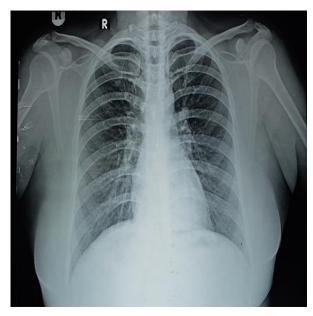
Immediate radiograph of chest.
